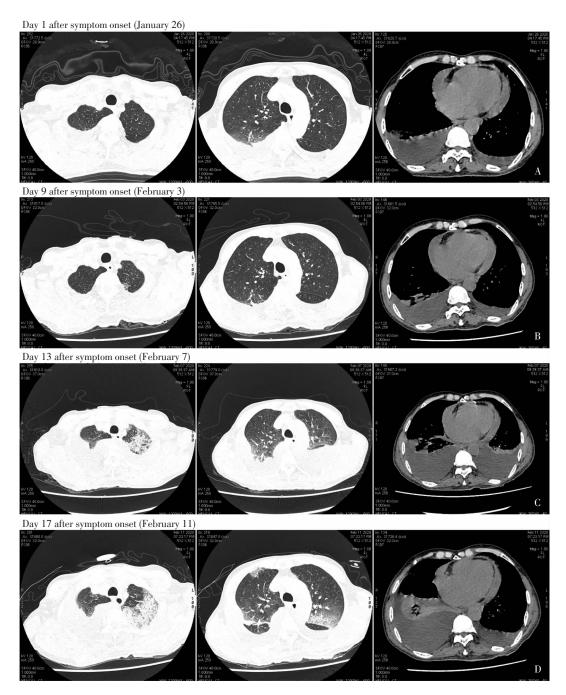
The course of chest CT images of case 8
